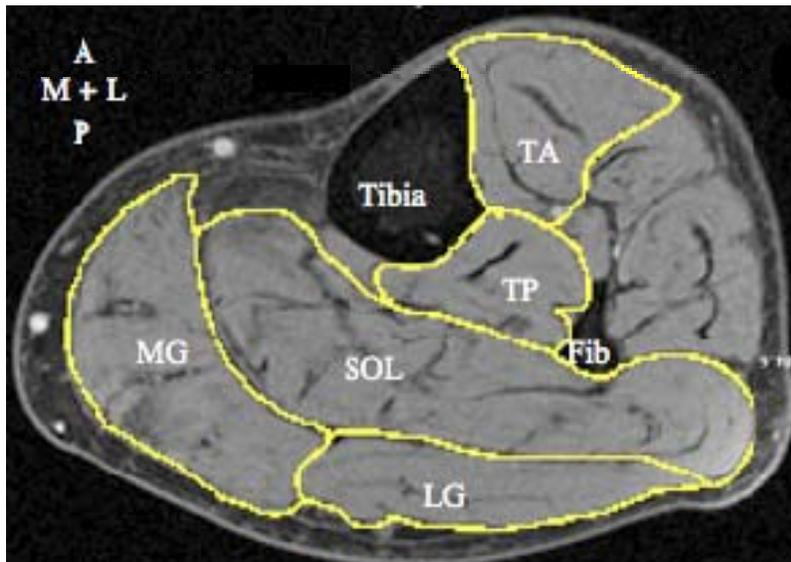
Representative ^1H -MRI trans-axial image of the calf muscles from a healthy control at 1.5T. A 3D fast gradient echo imaging sequence was used in a 1.5Tesla magnet. (A= anterior; P=posterior; M= medial; L=lateral)
